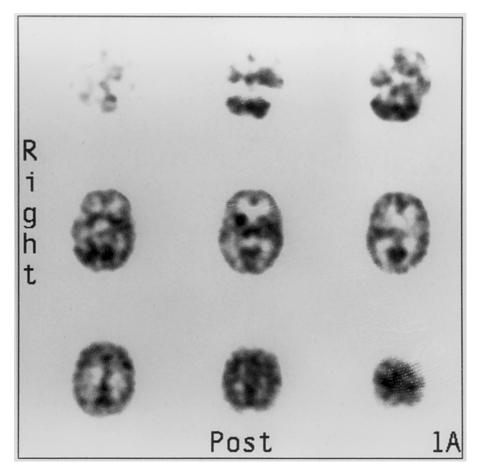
HMPAO SPECT scan of a patient with acute head injury demonstrating significant hyperemia in the right basal ganglia. The remainder of the cerebral perfusion is within normal limits (Reprinted with permission from Alavi A, Hirsch LJ: Studies of central nervous system disorders with single photon emission computed tomography and positron emission tomography: Evolution over the past two decades. Sem Nucl Med 21:58-81, 1991).
